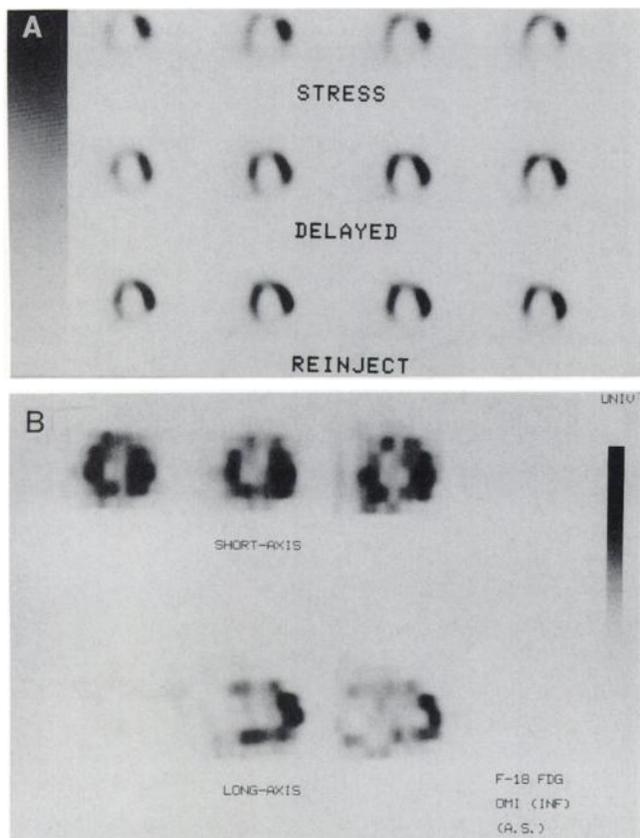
(A) A series of short-axis slices of stress (top), delayed (middle), and reinjection (bottom) ^{201}Tl SPECT images of a patient with inferior wall myocardial infarction. Note initial perfusion defects in anterior, septal and inferior regions with redistribution in septal and anterior regions. However, persistent defect is observed in inferior wall even after reinjection. (B) A series of short-axis and long-axis slices of FDG images show diffuse persistent uptake of FDG, including in inferior wall.
